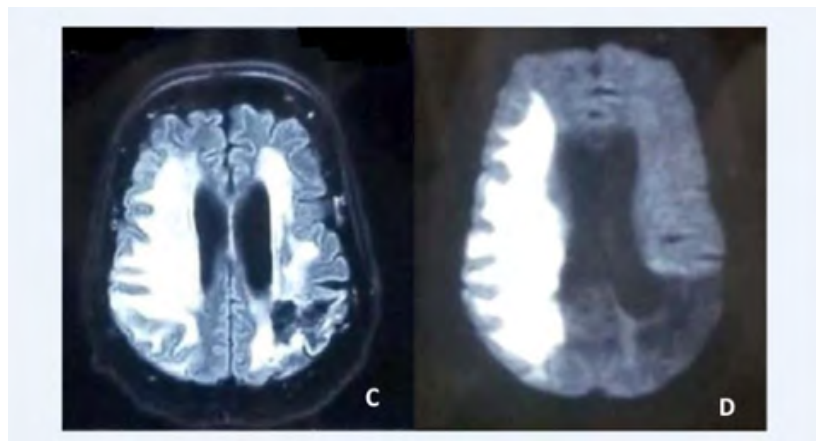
Brain MRI in T2-weighted echo sequence axial section (C) of bi-hemispheric hypersignal areas in T2 Flair taking the right fronto-parieto-temporo-insular and left fronto-parietal regions, appearing in b1000 diffusion hypersignal on the right and hypersignal diffusion on the left (D).
